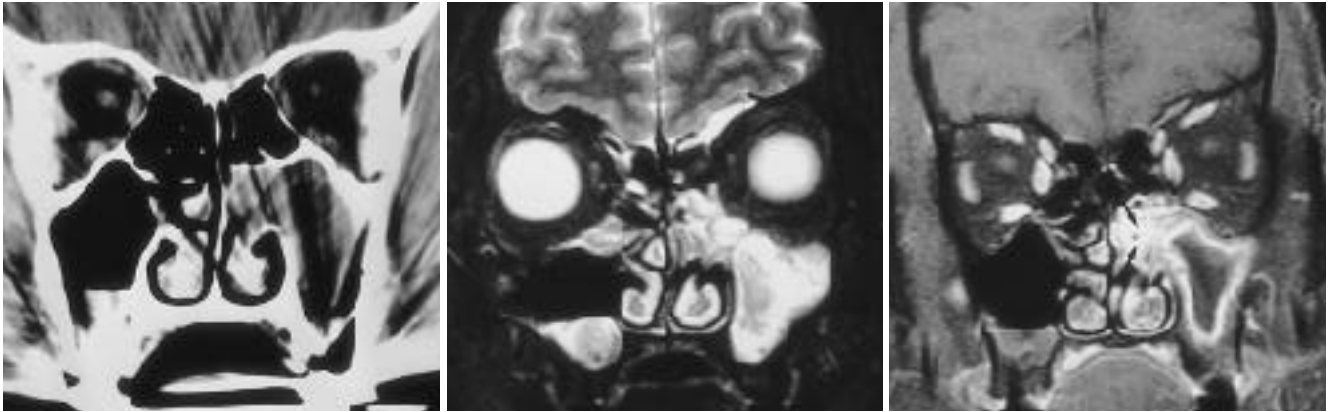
A. Nasal polyp. On contrast enhanced CT, beam hardening artifact from tooth amalgam hinders demonstration of enhancement pattern.
